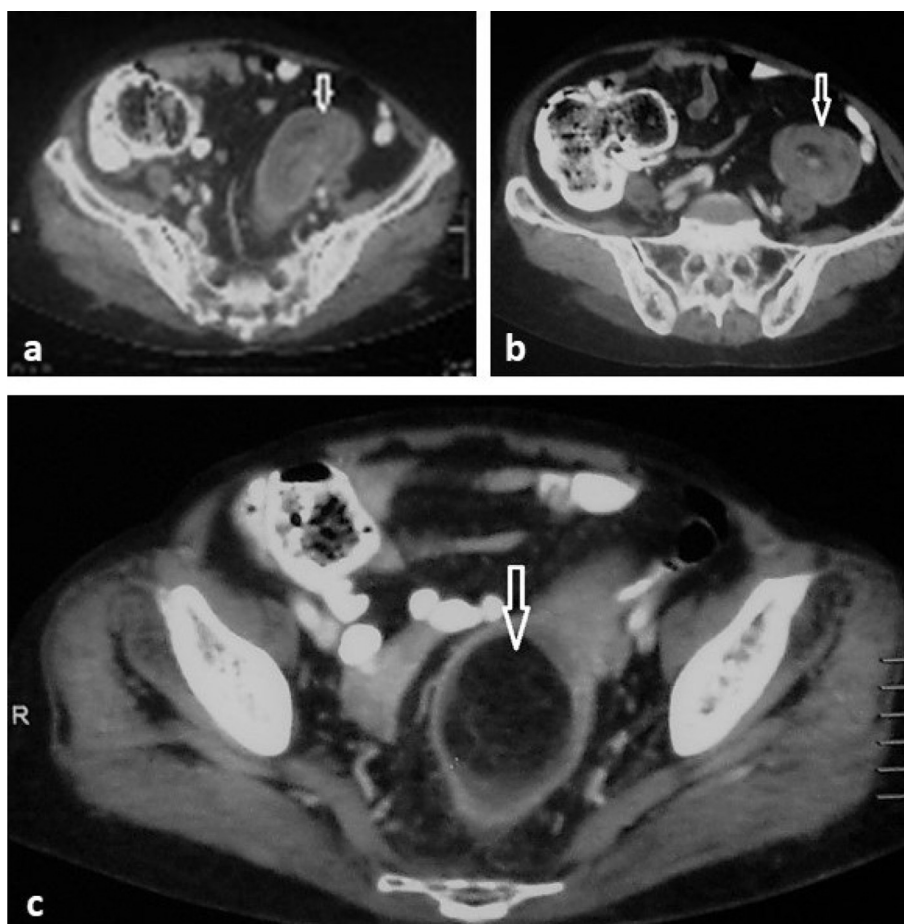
Axial CT images of the abdomen of the same patient with intravenous and oral contrast a) demonstrate the “sausage sign” of intussusception in the left iliac fossa, b) demonstrate the “target sign” of intussusception formed by concentric layers, including hypodense and hyperdense tissues, and c) reveal an ovoid, well-defined, hypodense mass of 7×5 cm inside the sigmoid colon. The attenuation coefficient of the mass was compatible with adipose tissue (lipoma).
